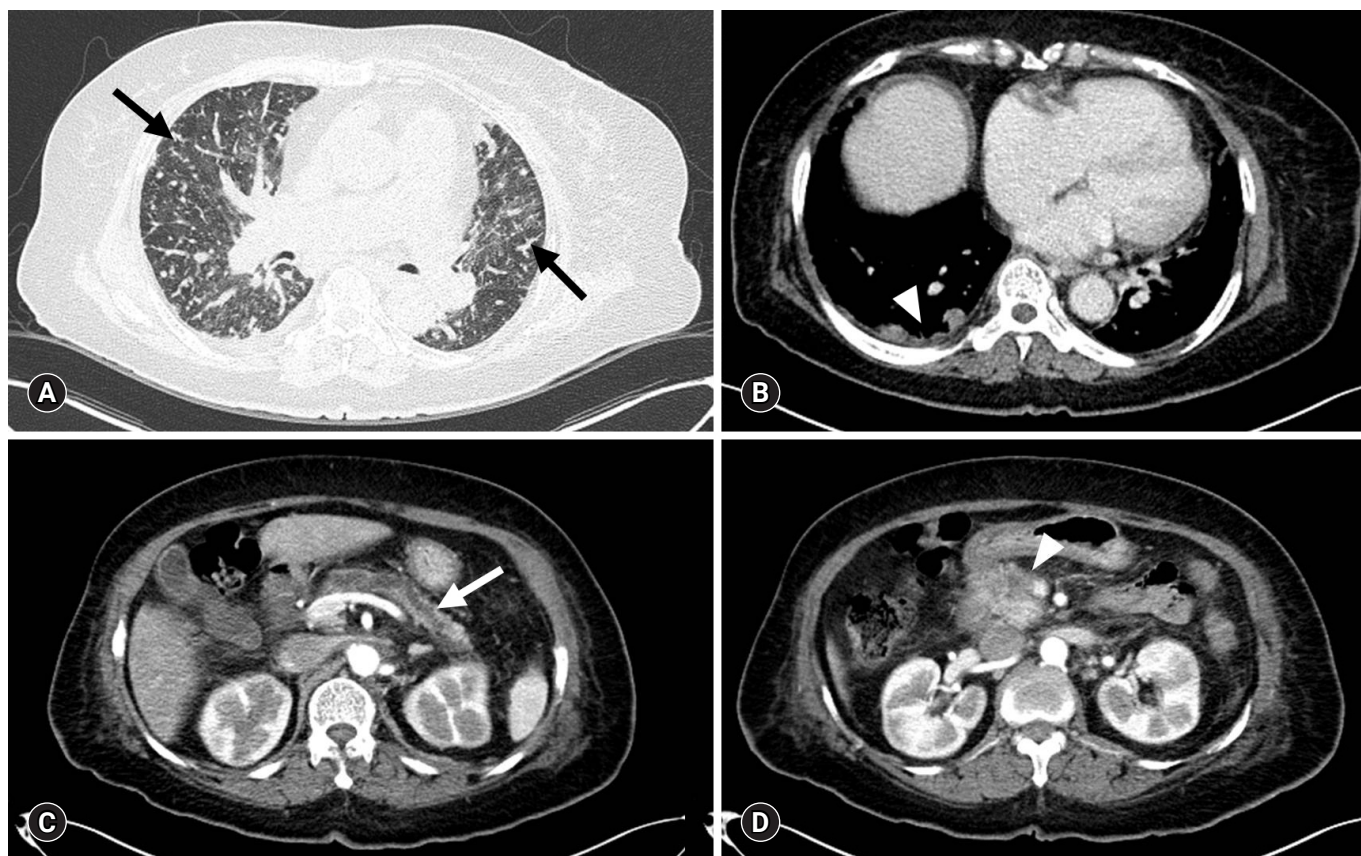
Contrast-enhanced CT. (A) Chest CT (lung window) with centrilobular nodules with "tree-in-bud" sign (arrows). (B) Chest CT (mediastinal window) with pleural-enhancing nodules (arrowhead). (C) Abdominopelvic CT show upstream pancreatic duct dilatation (arrow). (D) Abdominopelvic CT with pancreatic head neoplasm (arrowhead). CT, computed tomography.
